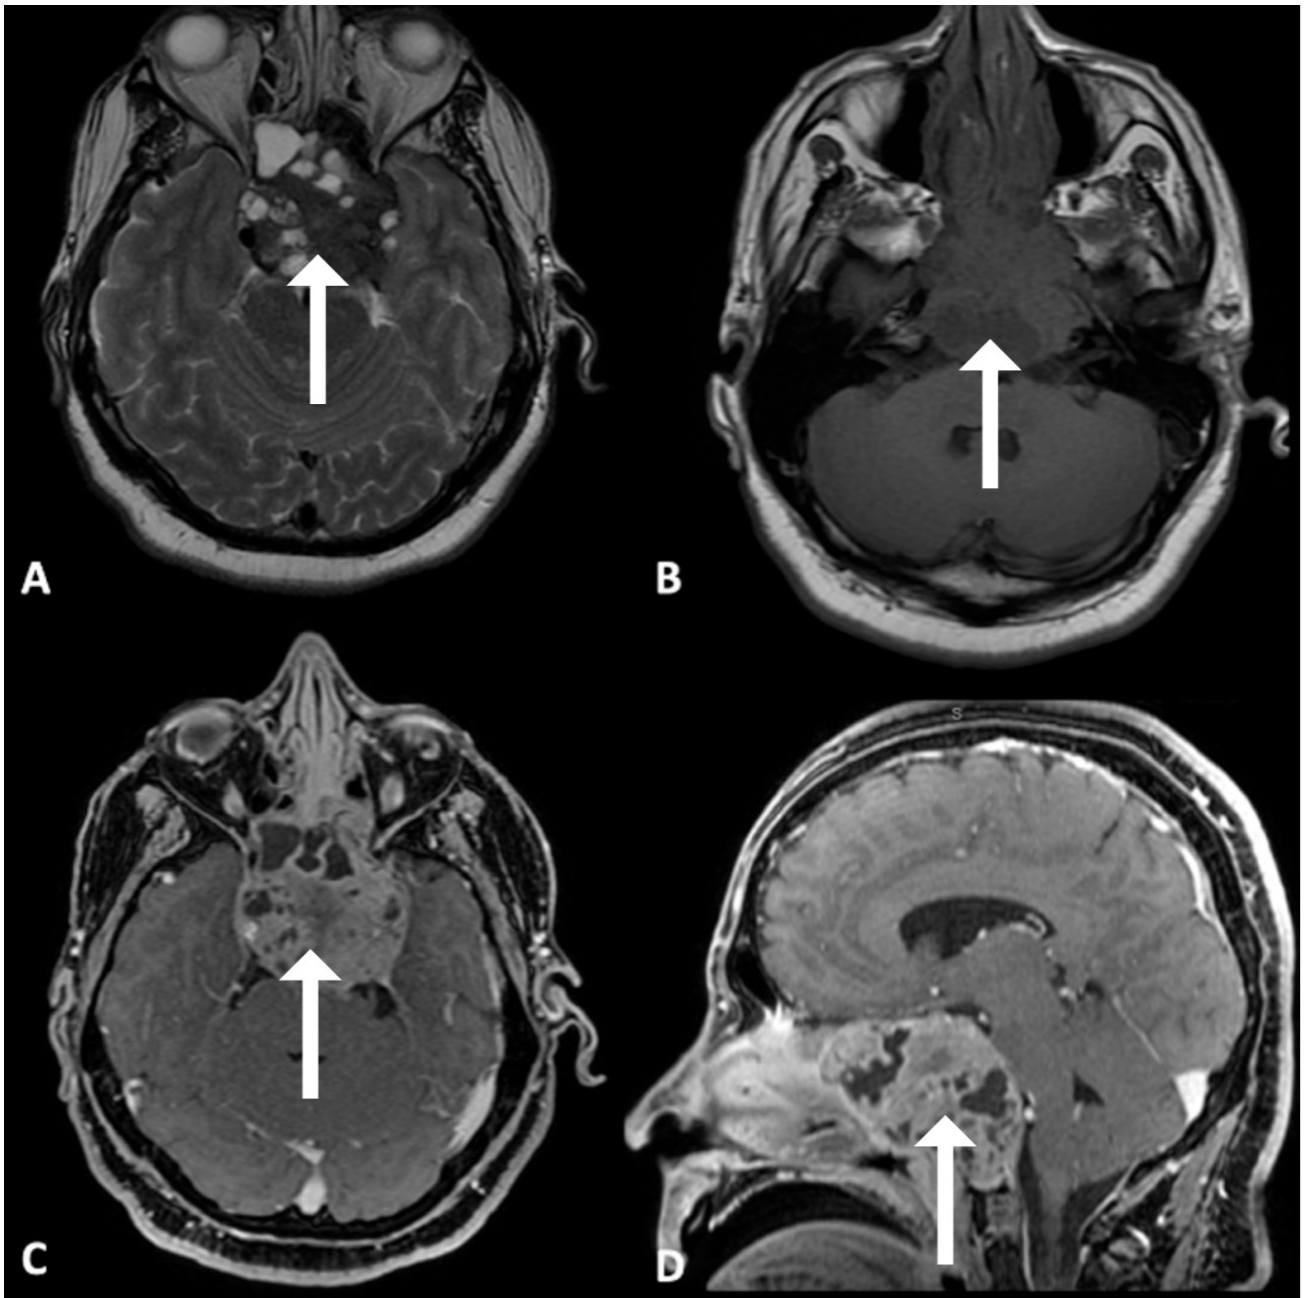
Contrast-enhanced MRI of a giant cell tumor of bone (GCT) of the clivus. (A) Axial T2-weighted MRI demonstrates a lobulated expansile lesion centered in the clivus. The arrow indicates posterior extension into the prepontine cistern with mass effect on the ventral surface of the pons. (B) Axial T1-weighted MRI shows the lesion as predominantly isointense to brain parenchyma. The arrow highlights the region of clival cortical involvement and marrow replacement. (C) Axial contrast-enhanced T1-weighted MRI (T1+C) reveals marked heterogeneous enhancement with probable extension into adjacent skull base compartments. The arrow indicates the petroclival extension adjacent to the cavernous carotid region. (D) Sagittal contrast-enhanced T1-weighted MRI (T1+C) demonstrates extensive clival destruction with superior extension toward the dorsum sellae and inferior extension toward the basiocciput. The arrow indicates posterior displacement and compression of the brainstem. (Personal archive; patient informed consent was obtained.)
